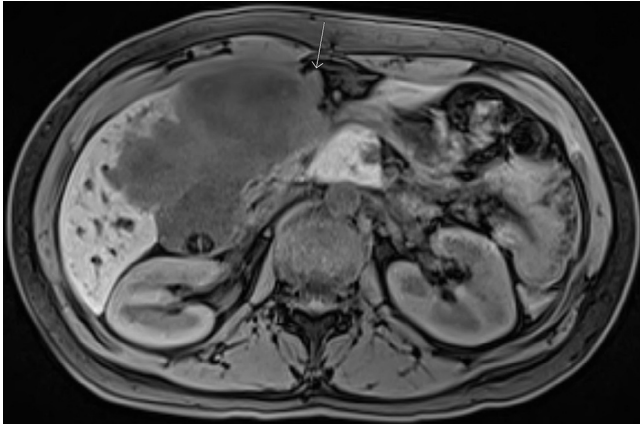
Axial T1-weighted precontrast image demonstrates heterogeneous, predominantly hypointense hepatic lesions, a peritoneal lesion (arrow), and cholelithiasis within the gallbladder.
